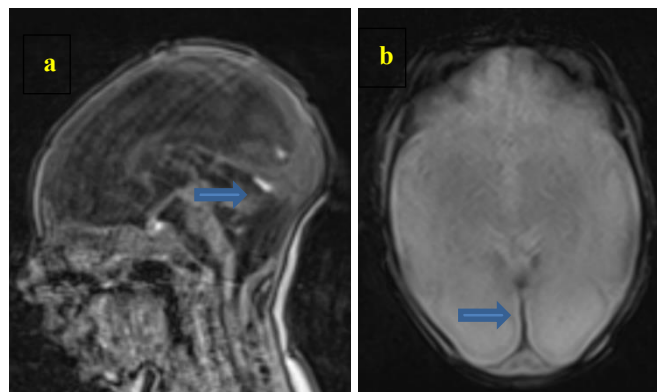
seconde case : Abnormal signal involving the tentorium cerebelli and falx cerebri, hyperintense on T1-weighted images (a) and showing signal void on T2* sequences (b), suggested a hemorrhagic component
